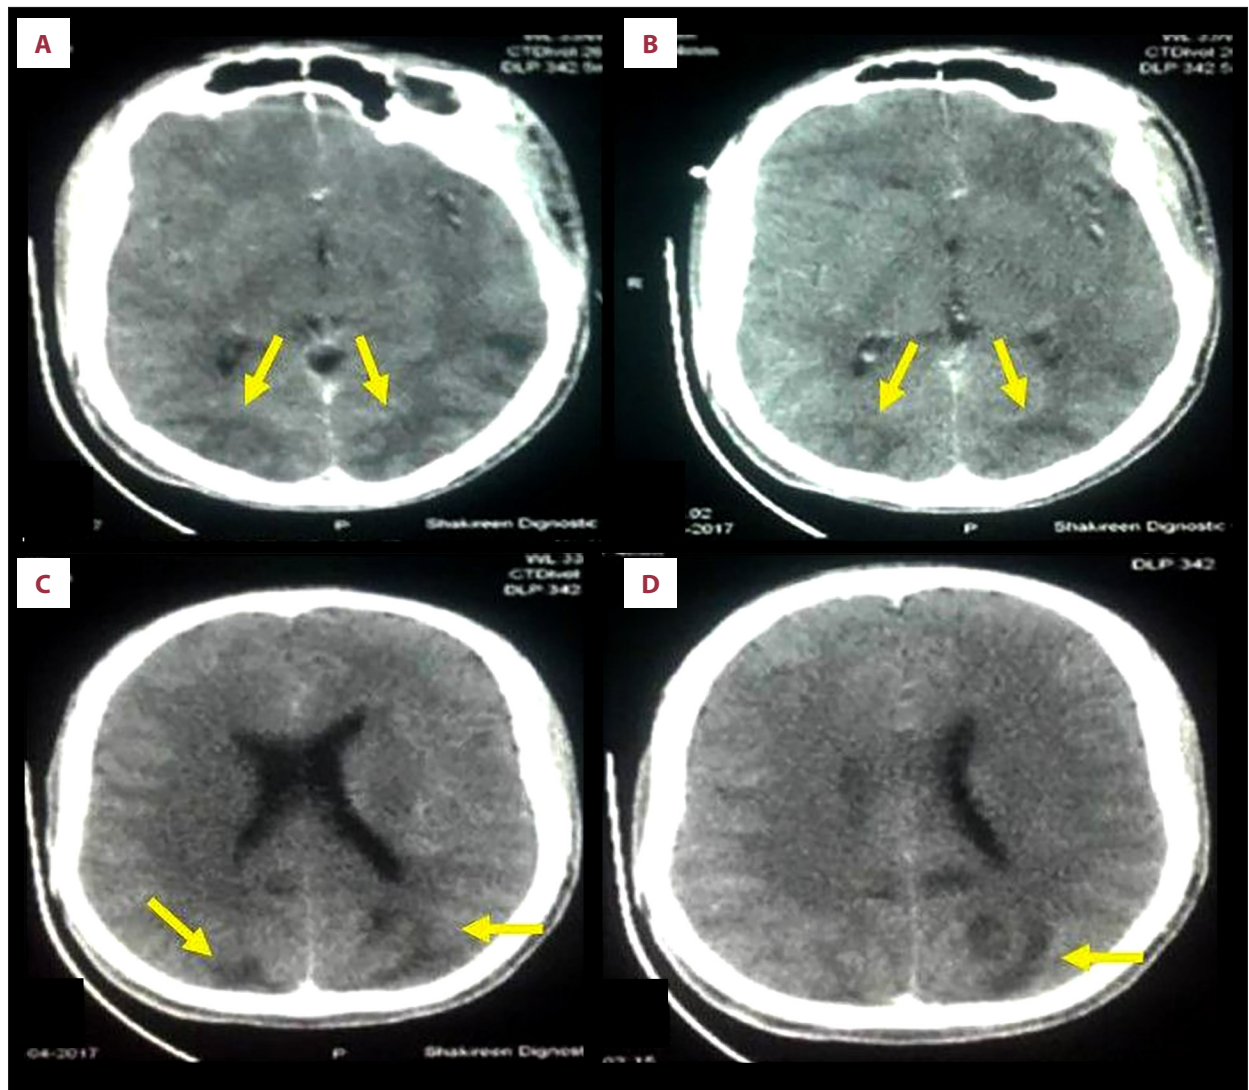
Axial unenhanced CT brain images (A-D) at different levels demonstrate bilateral, ill-defined hypoattenuation predominantly involving the subcortical white matter of the occipital lobes (yellow arrows), consistent with vasogenic edema. The remainder of the brain parenchyma appears preserved.
